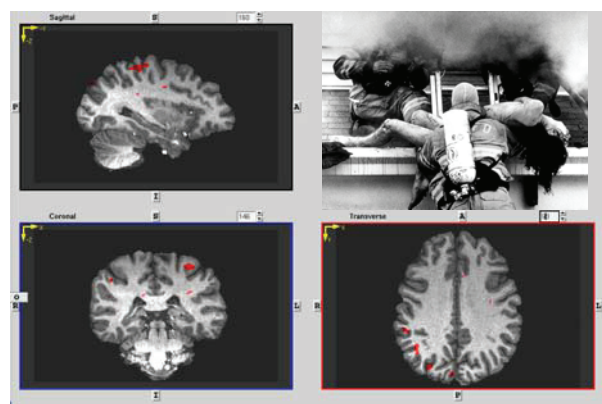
Functional MRI for patient CC at 2 weeks of therapy, showing multiple areas of interferon-induced CNS activation. A representative section of the brain MRI of one of the subjects (CC) who did develop CNS symptoms (clinically significant depression) after interferon therapy, in this case after only two weeks of INF. Visual stimulus #4 (Figure 4) was used to generate this scan. There is a significant increase in multiple activation areas (red areas) over baseline (Figure 9, Table 2). There was also a significant increase in the Beck Depression Scale (Table 1) over baseline.
